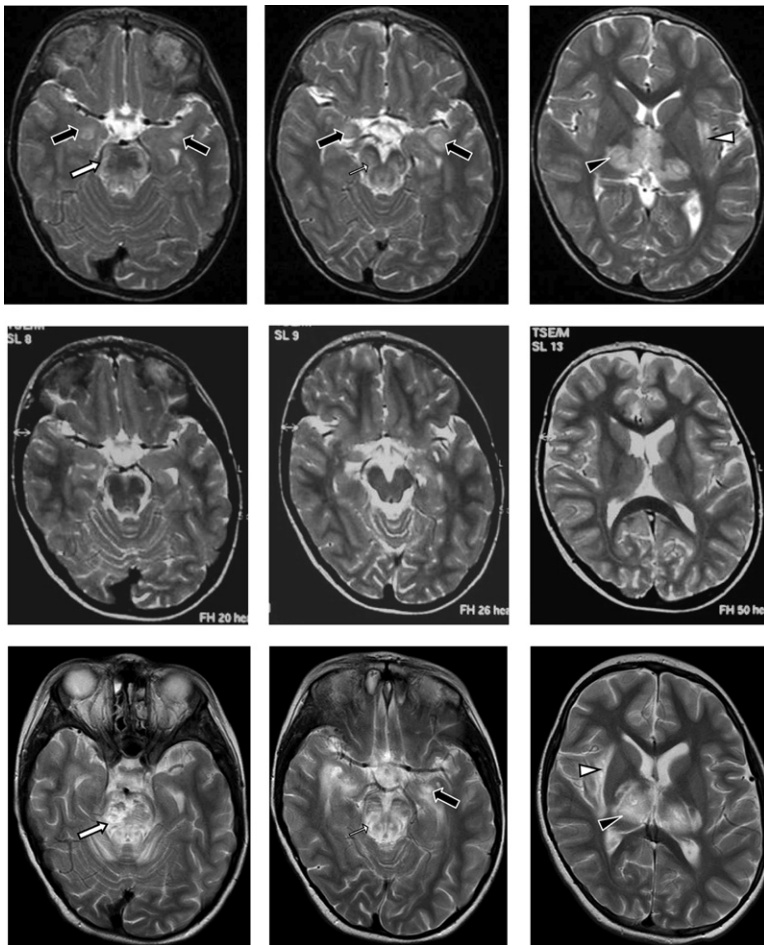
Brain MRI Findings in a Child (690, II:1) with Familial and Recurrent Acute Necrotizing Encephalopathy
